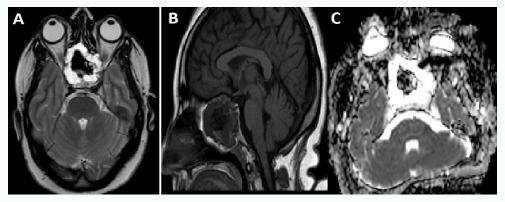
T2-weighted axial (A), T1-weighted sagittal (B) and diffusion-weighted ADC maps (C) MRI scans shown in a mass originating from the sphenoid bone, with signal void at all sequences in central areas, and without diffusion restriction.
